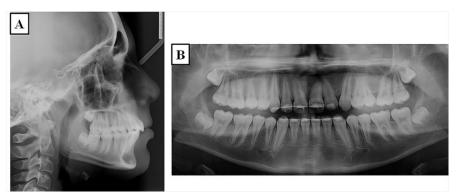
A, B: Radiographs after the completion of treatment
